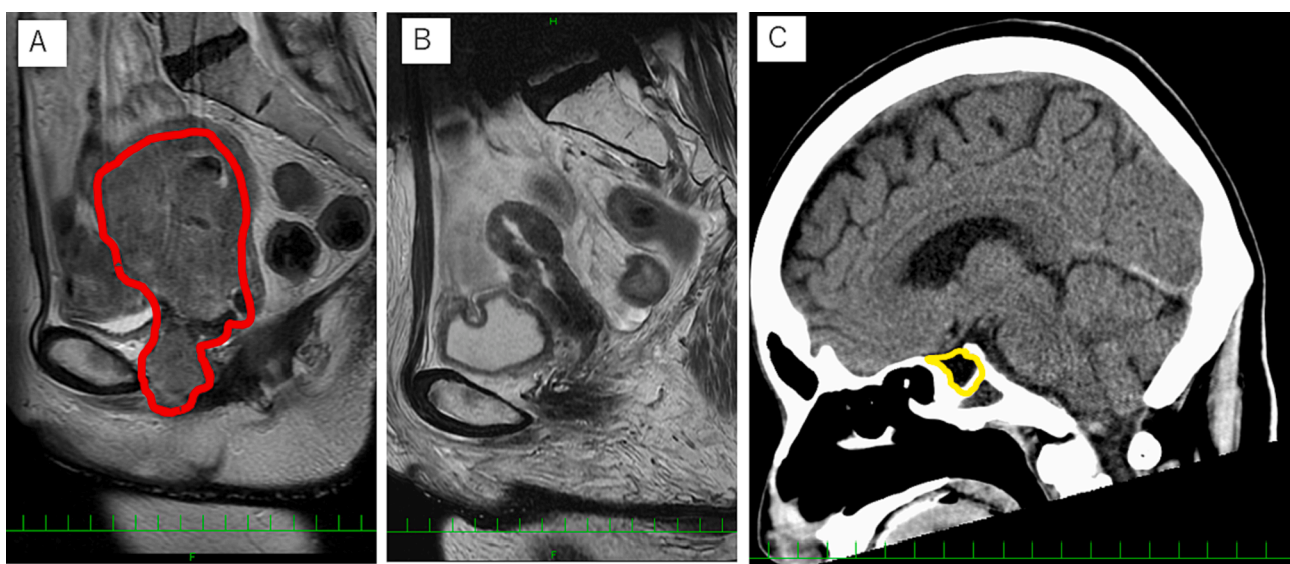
Head CT and pelvic MRI finding. A: MRI at the initial visit shows tumor invasion from the uterus to the vulva (area surrounded by a red line). B: MRI after completion of radiotherapy shows a complete tumor response. C: CT at the initial visit. The herniation of the subarachnoid space within the sella turcica is visible (area surrounded by a yellow line). Based on these findings, the patient is diagnosed with a primary empty sella. CT, computed tomography; MRI, magnetic resonance imaging.
